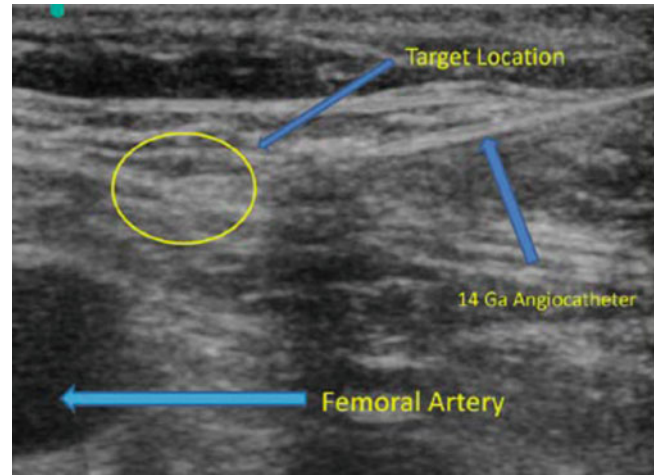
Cryoneuroablation under ultrasound of the genitofemoral nerve (Image courtesy of John Chiles, MD)
